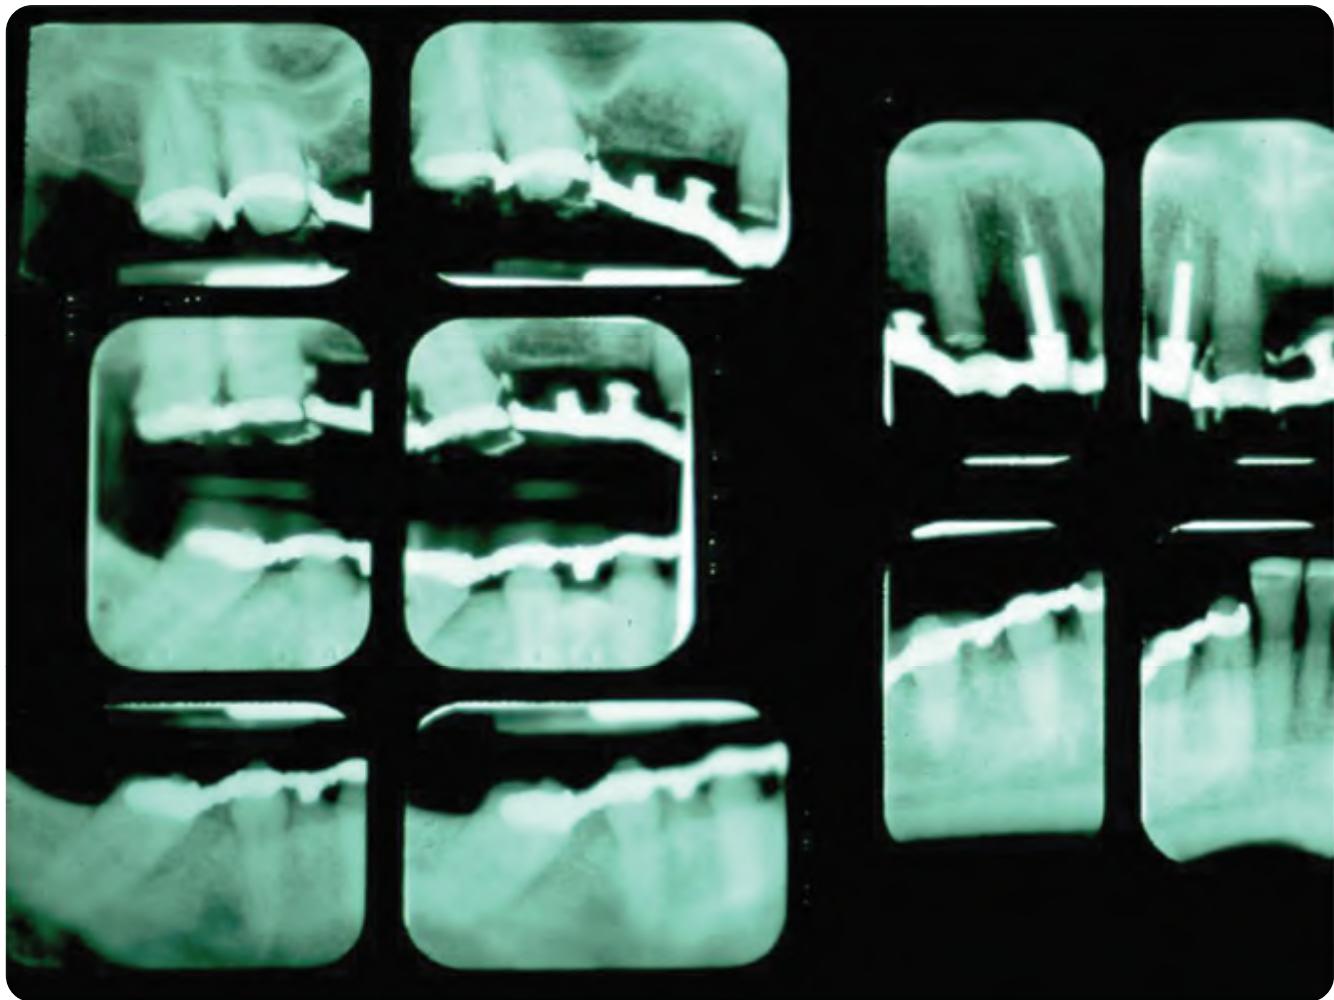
Pretreatment radiographs, right side. Note excessively large post in upper right lateral incisor and no clinical crown on upper right cuspid.
